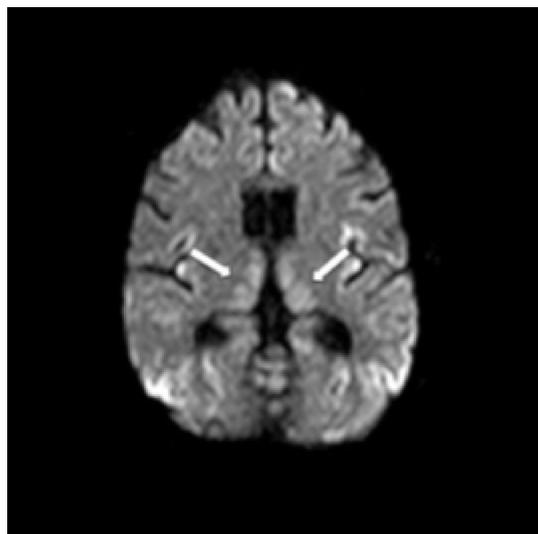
Hyperintense signal in the MRI diffusion-weighted images showing in bilateral thalami
